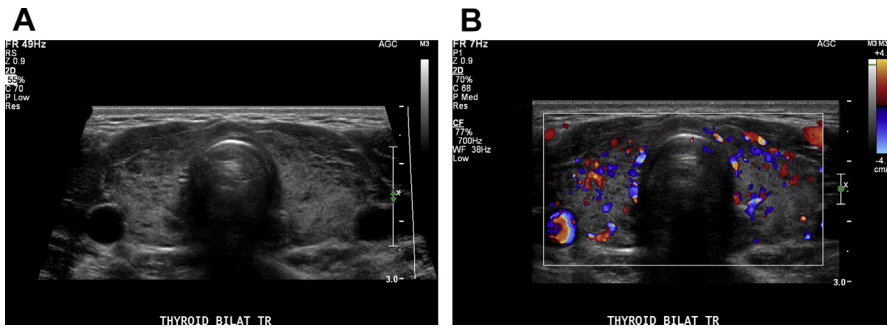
A 39-year-old woman with Hashimoto thyroiditis. (A) On gray-scale, small patchy hypoechoic nodules scattered diffusely throughout the gland in the transverse plane. (B) Color Doppler can be increased in the acute phase, as in this patient, shown in the transverse plane.
